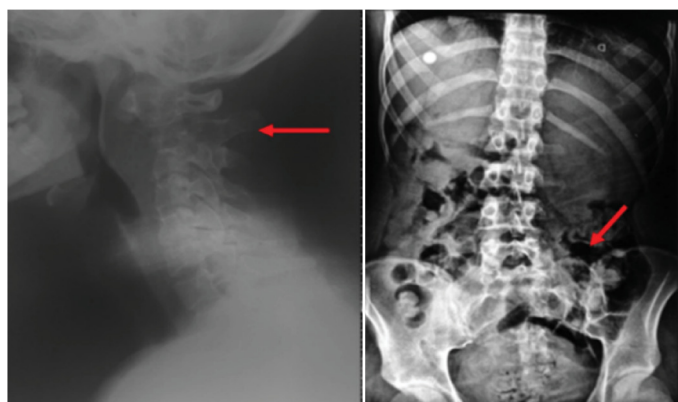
Left: Cervical profile X-ray. Right: Lumbosacral and pelvic view. Both X-rays show an osteolytic lesion invading C2 and the right sacrum, respectively.
